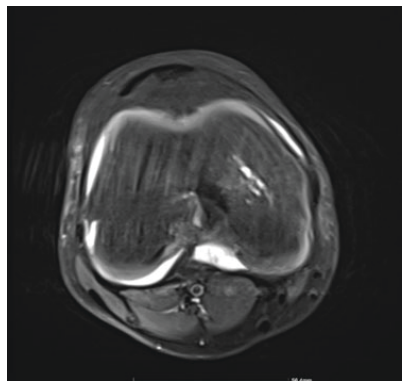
Axial MRI sequence, demonstrating the cystic lesions in the medial femoral condyle.
